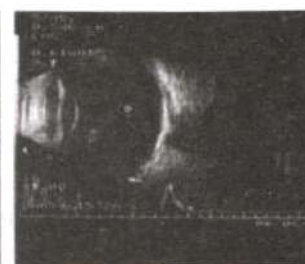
B scan ultrasound showed high surface reflectivity with posterior shadowing suggestive of ossification
